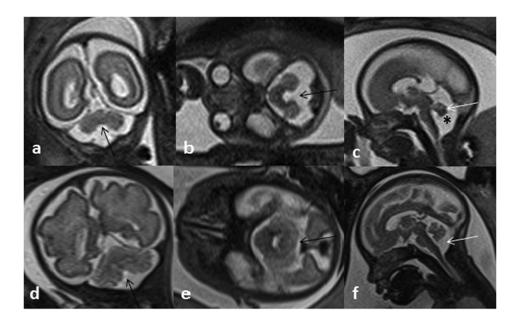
Fetus at 22 weeks + 4 days of gestation. Magnetic resonance imaging (MRI) shows enlargement of cisterna magna. The axial and coronal planes (a, b) show apparent absence of the inferior portion of the vermis, but the sagittal plane demonstrates a normal appearance of the morphology and regular biometry (c, white arrow). The features and the absence of 'tail sign' (c, *) suggest the hypothesis of a vermian malrotation for a retarded closure. MRI at 30 weeks + 5 days shows a normal vermis (d, e) with a complete closure (f). The finding confirms the first MRI diagnosis
